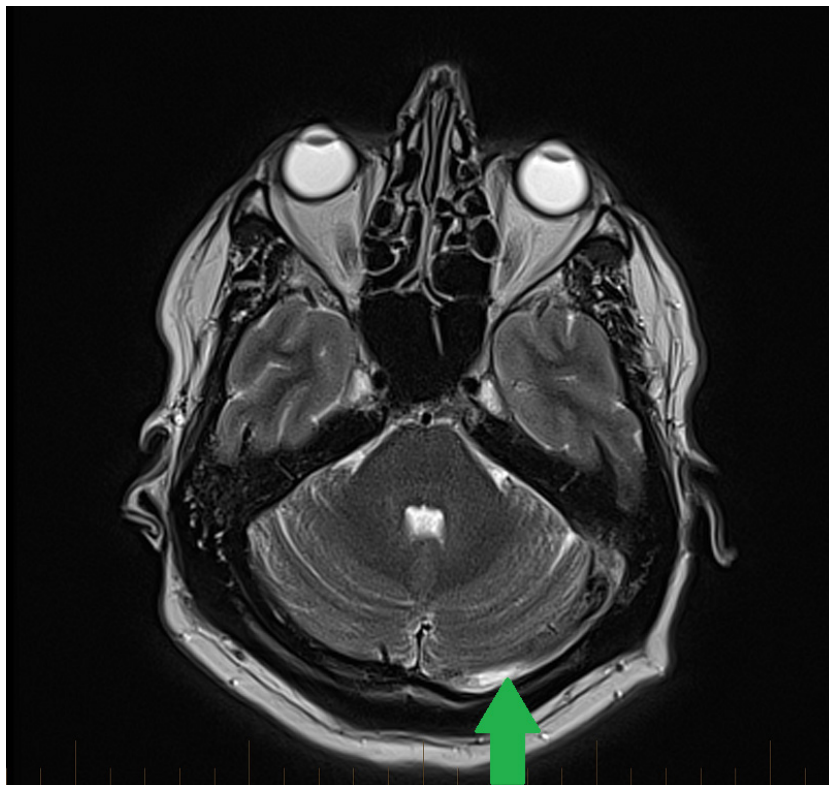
T2-weighted magnetic resonance venogram (MRV) of the brain with Gadolinium contrast demonstrating thrombus in the left transverse sinus, denoted by the green arrow.
